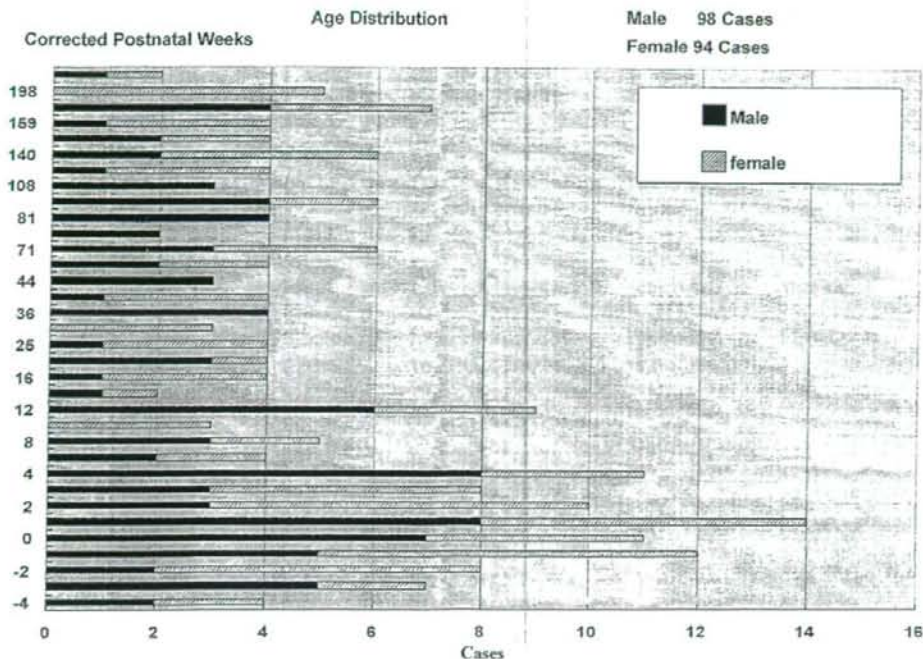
Histogram shows the age distribution of MRI. We examined a total of 192 neonates, infants and small children (98 males, 94 females), with a mean age of 8.7 weeks (range, -4 to 224 corrected postnatal weeks, with minus weeks indicating a premature infant).
